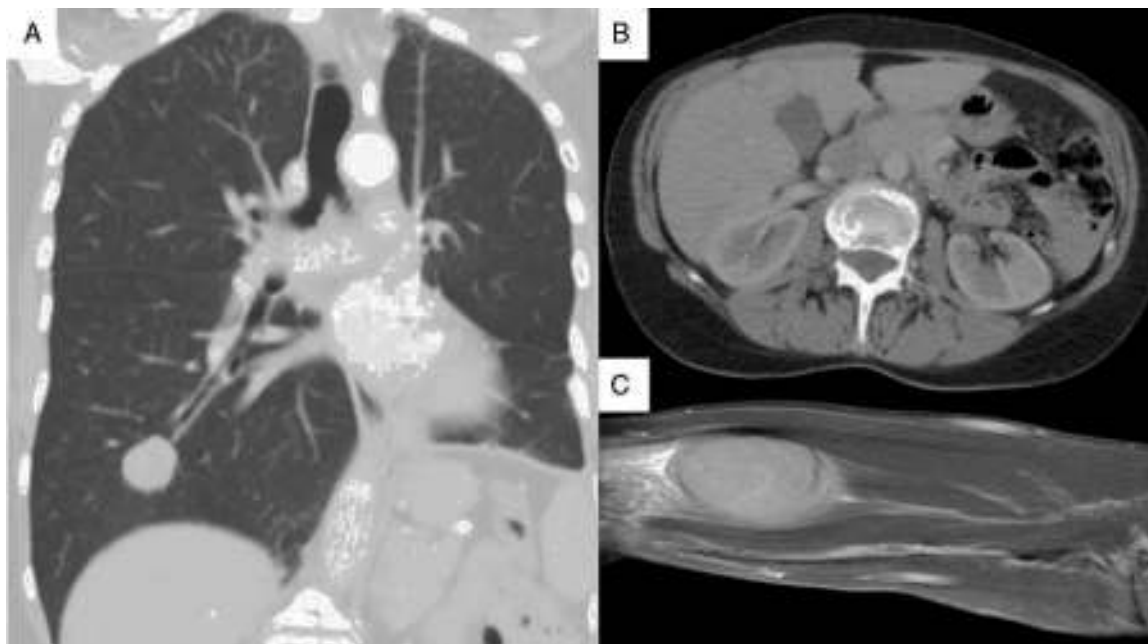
(A) Chest computed tomography, showing a 25-mm nodular image in the basal segment of the right lung field. (B) Tomography slice of the abdomen, showing a mass in liver segment V, measuring approximately 30 mm. (C) Magnetic resonance image of nodular formation located between the muscle planes of the palm and distal third of the right forearm, 50 mm×30 mm×20 mm.
